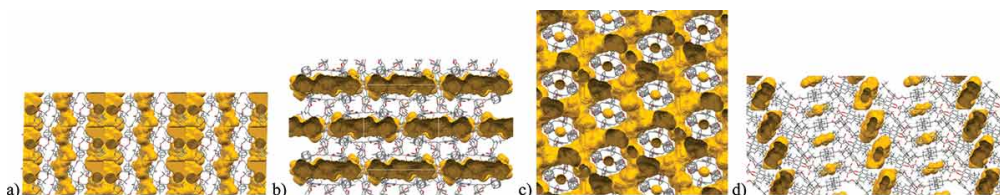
Accessible void volume of X-ray structures of a) 1 α , b) 1 β , c) 3 α and d) 3 β .
